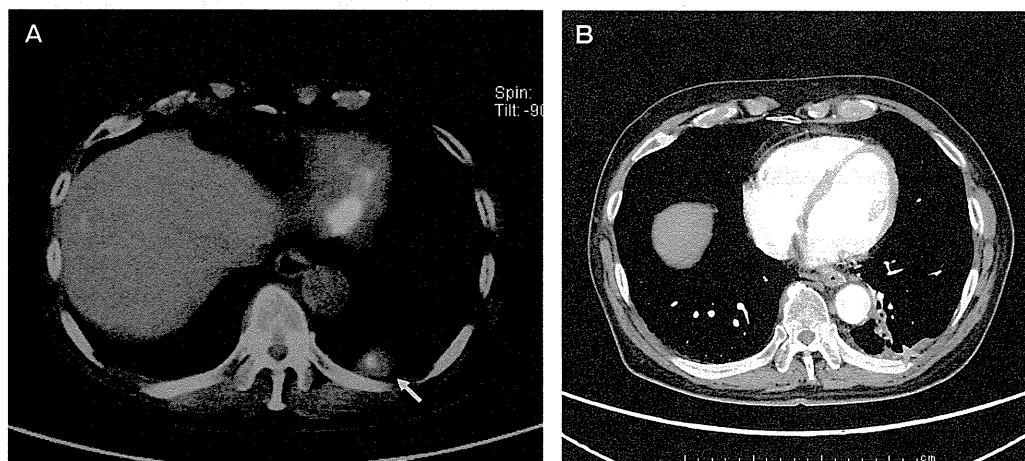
A, Pre-RFA PET/CT of a 67-year-old male without local recurrence. The PET/CT showed a metastatic lesion in the left lung from primary rectal cancer (oblique arrow). The metastatic tumor was treated by RFA. The SUV_{max} in the tumor was 2.36; B, The follow-up CT examination was performed 25 months after RFA. The contrast-enhanced CT shows no irregular enhancement (arrow head).
